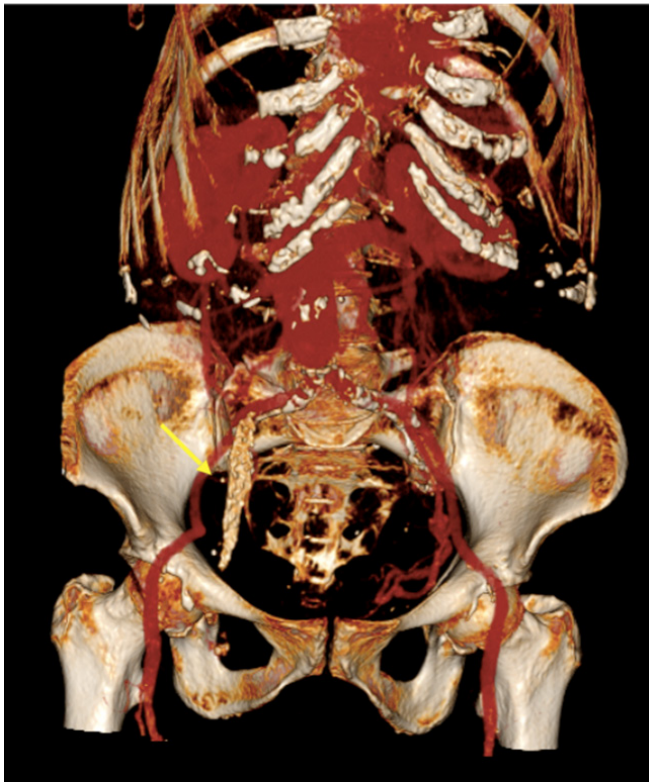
Three-dimensional reconstruction of CT of the abdomen showing a gallbladder full of calculi extending to the femoral region (arrow).
